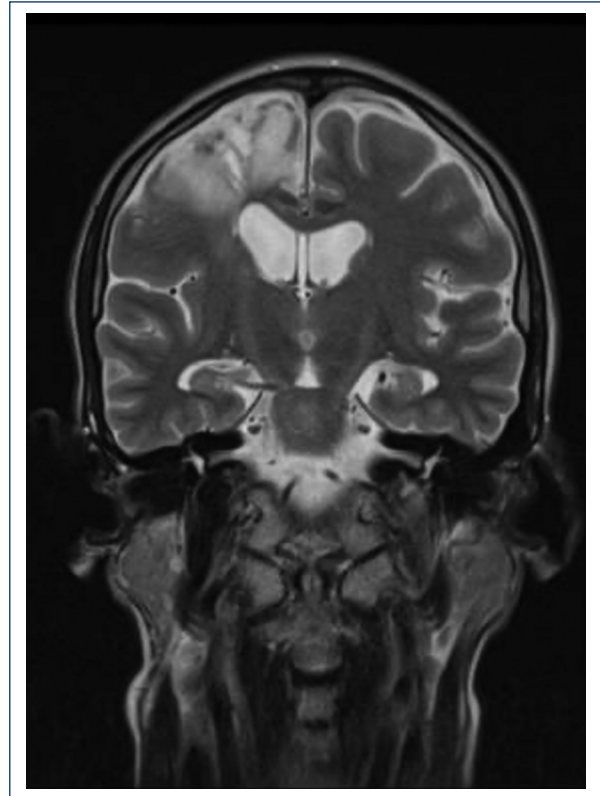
Magnetic resonance imaging shows right frontal leptomenigeal enhancement associated with encephalomalacia.
